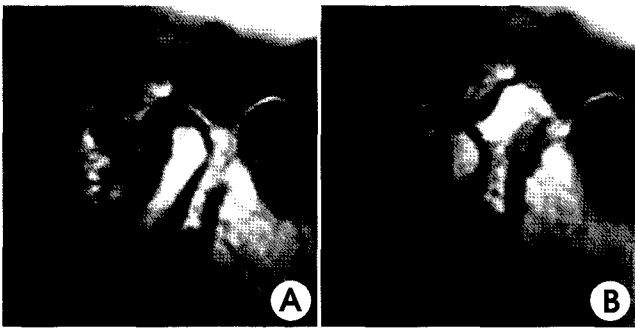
MR images show anterior disc displacement without reduction (A: close, B: open).
